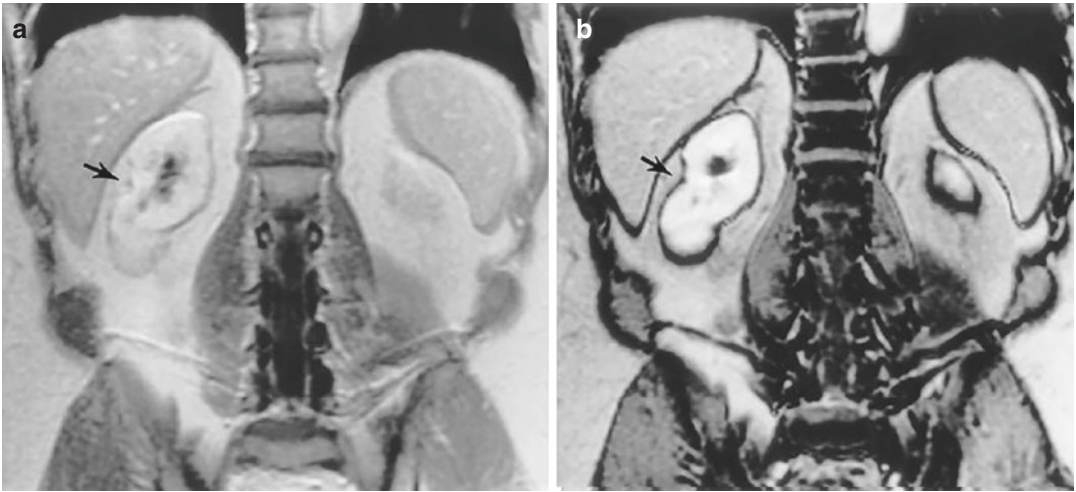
Chemical shift artifacts seen on (a) in-phase and (b) out-of-phase kidney MR images
